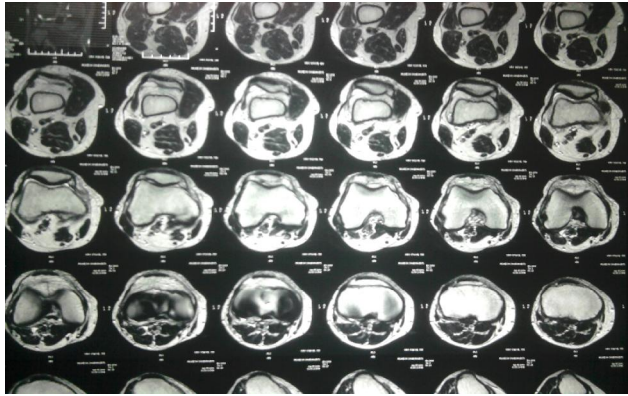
Showing MRI of ACL tear
